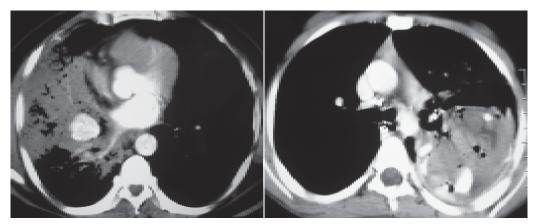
Contrast-enhanced CTs of two different patients with community acquired necrotizing pneumonia demonstrating an uncommon but potentially life-threatening complication of infective pulmonary aneurysm. The CT films show the presence of contrast enhanced densities within the areas of consolidation consistent with the presence of vascular aneurysm
